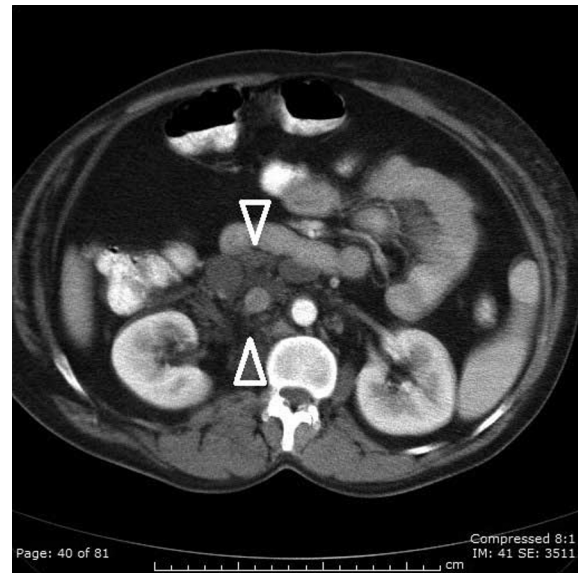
Proteus Syndrome in a 26-year-old male. Axial CT. Note striking para-aortic lymphadenopathy versus conglomerate soft-tissue mass (white open arrowheads).
